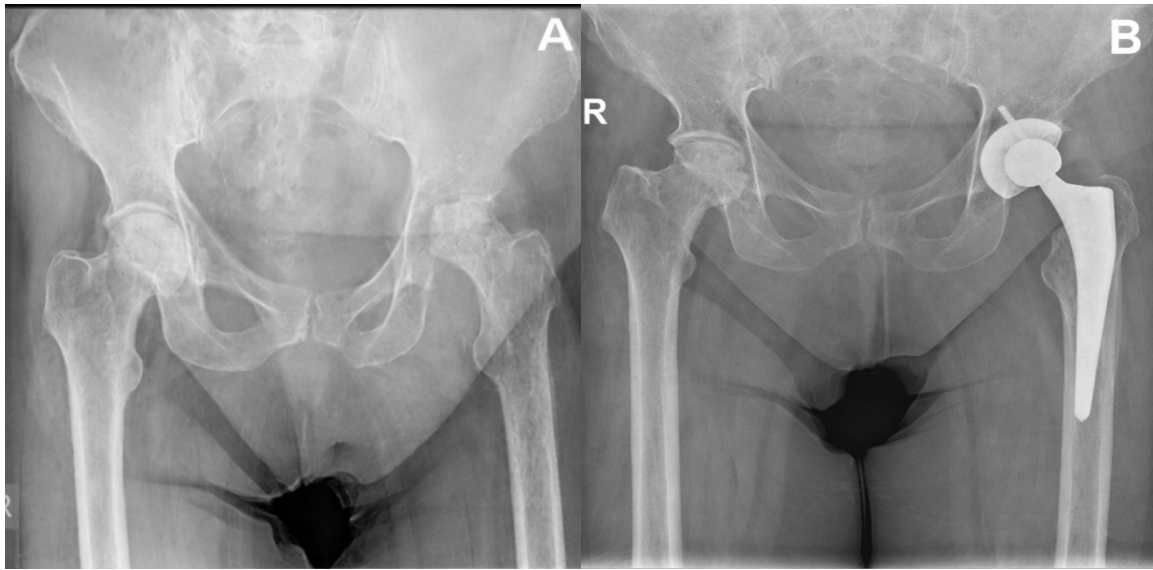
(A) Preoperative anteroposterior pelvic X-ray. (B) Postoperative anteroposterior pelvic X-ray.
